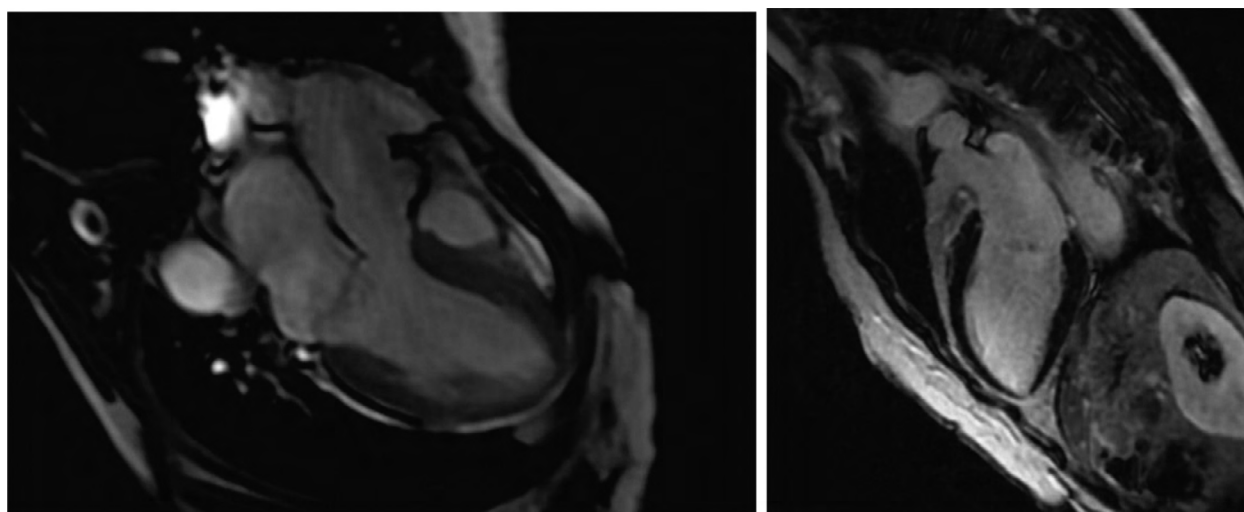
Myocardial magnetic resonance imaging. Phase of delayed contrast enhancement
